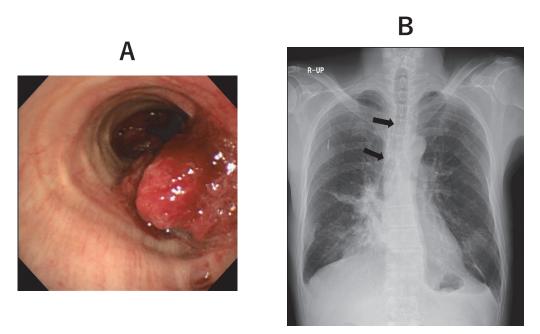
Bronchoscopy and chest X-ray film in case 1
